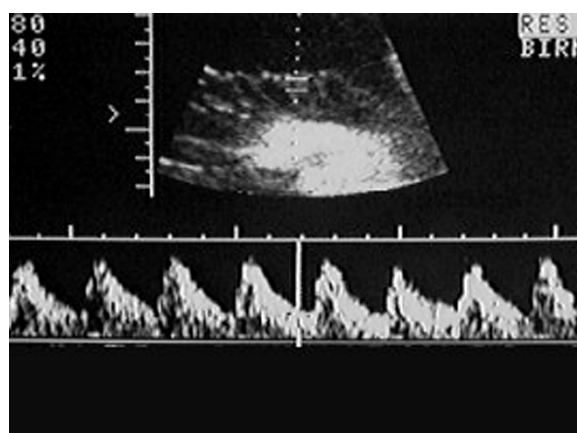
Normal umbilical artery Doppler wave form at 34 weeks' gestation
